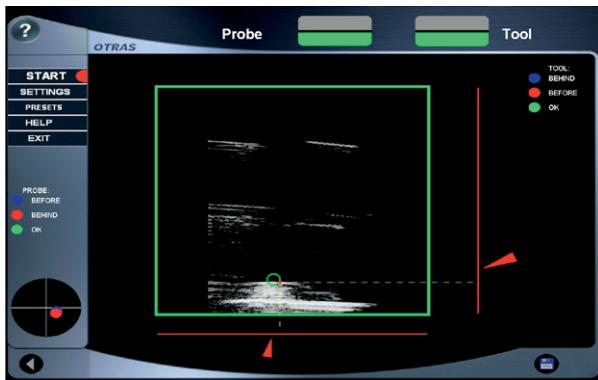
Tracking. Target structure in the ultrasound image (green circle). The red navigation aids (bars, arrows, point) indicate the distance to the target structure and the proposed insertion channel for the surgical instrument. When the target has been successfully touched, the color of the navigation aids will change to green.
